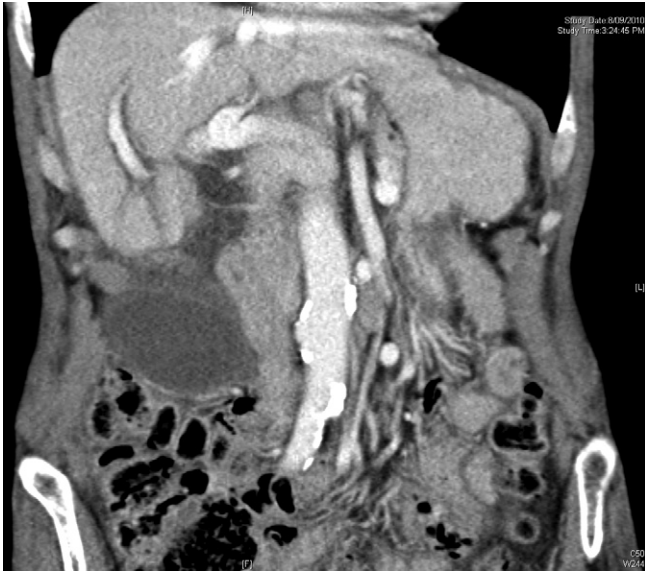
Computed tomography demonstrating a low-lying gallbladder with a diffusely thickened wall and pericholecystic fluid
